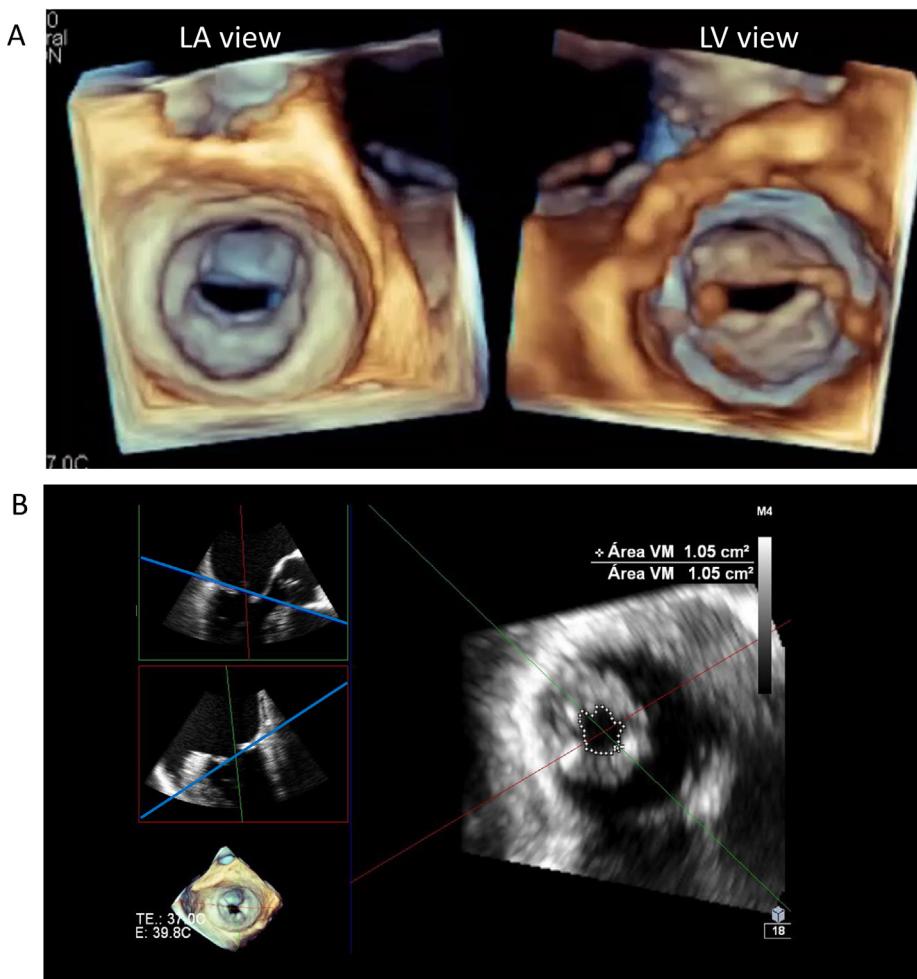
3D echocardiography of rheumatic MV. (A) Visualization of stenotic valve area from left atrial (LA) and left ventricular (LV) views. (B) Multiplanar imaging to guide the imaging plane (blue line) at the mitral valve tip for planimetry of irregularly shaped MV opening.
